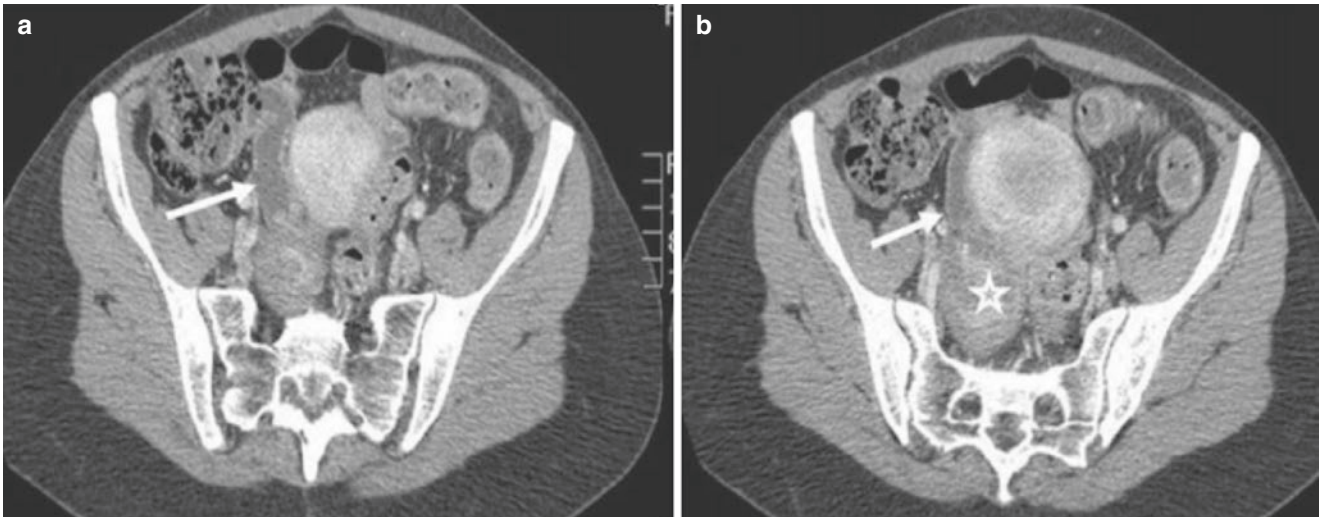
Tubo-ovarian abscess: CT scan showing nodular formation, with heterogeneous enhancement, located in the right adnexal region, that represents the inflamed ovary (*star b*). The uterine tube is dilated and has parietal enhancement, indicating pyosalpinx or salpingitis (*arrows in a, b*). (a, b) Axial sections obtained in the portal phase, after
